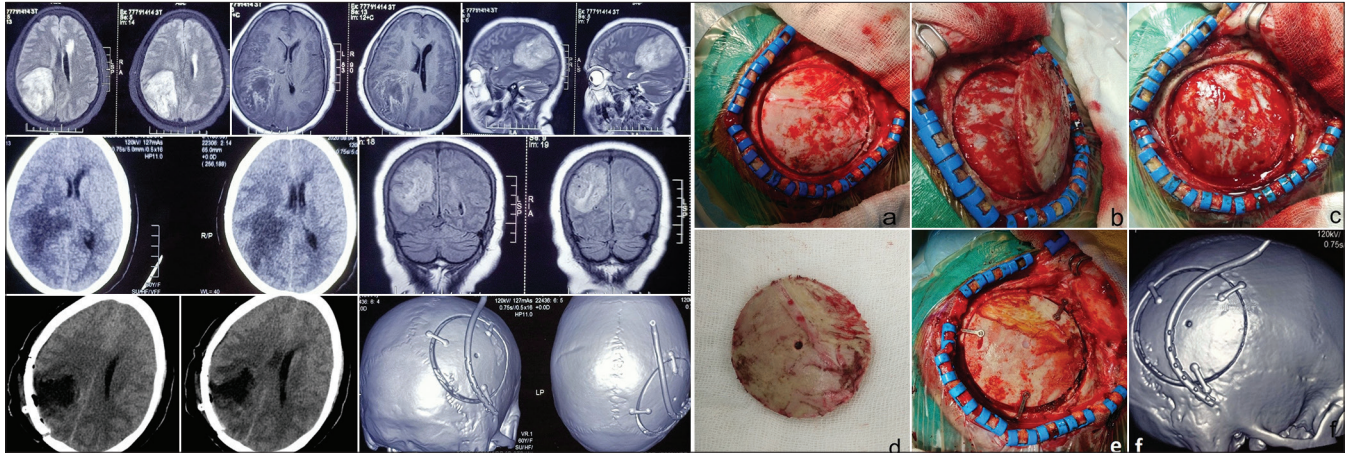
CT shows hypointense lesion in the right parietotemporal region with perilesional edema. The MRI was suggestive of a mass which was hypo on T1 and hyper on T2 sequence with heterogeneous enhancement on contrast. The findings were consistent with high-grade glioma (upper two rows). The lower row shows gross total excision of tumor on postoperative CT scan and 3D bone flap *in situ*. Intraoperative images showing trepanation over parietal bone (a), bone flap being lifted (b), craniotomy and bone flap (c and d), bone flap fixed using miniplates and screws (e), and 3D reconstructed image shows well-fixed bone flap in postoperative scan (f).
